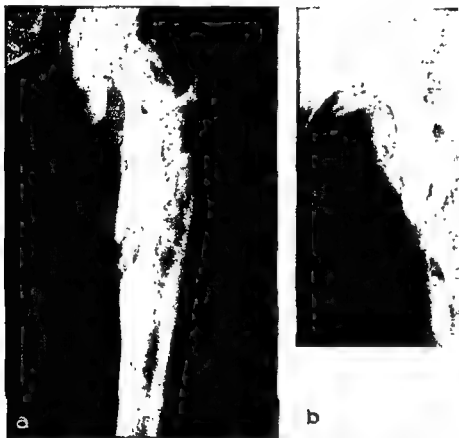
(Case R. T. D.). *a* and *b*, Admission roentgenograms with diodrast injection; osteomyelitis of five years' duration subsequent to a series of boils, multiple sinus tracts present.
